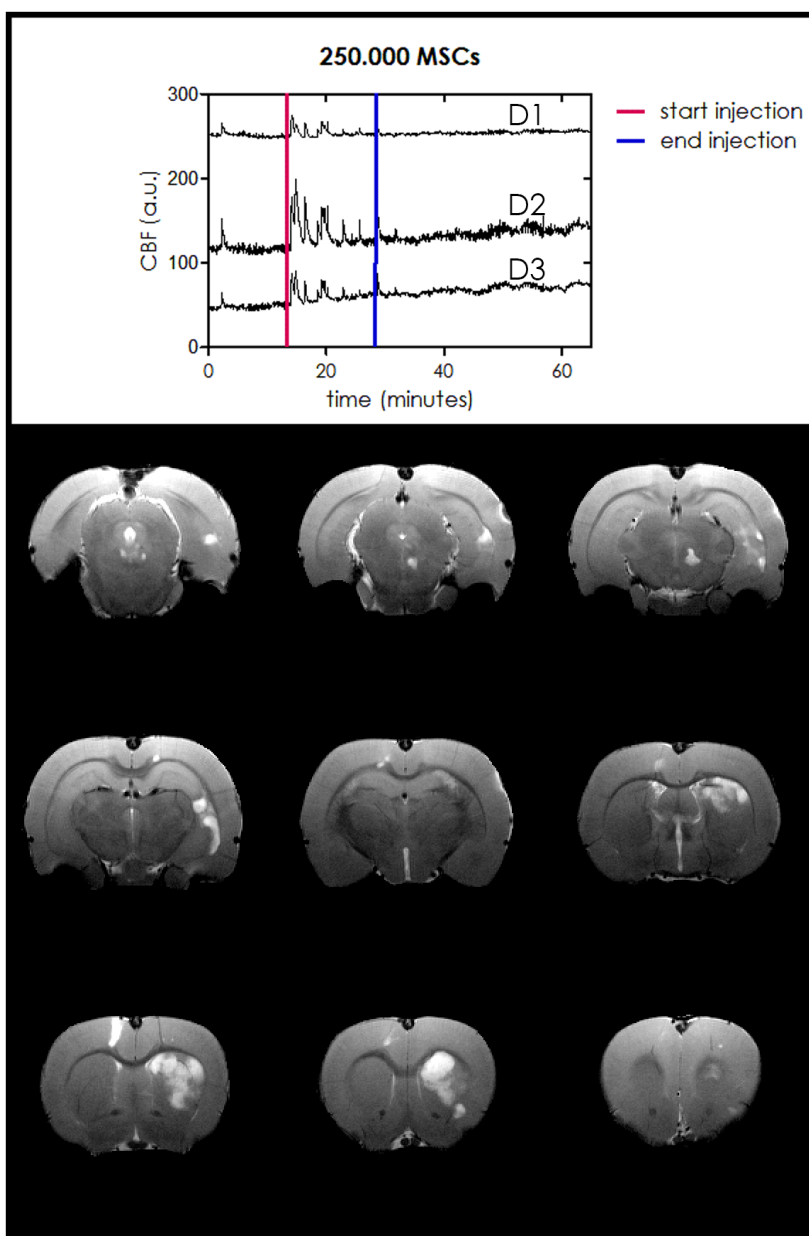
CBF for 3 Doppler probes measured before, during and after the injection of 0.25×10^6 MSCs; and MR T₂ weighted images of several brain slices 24h after the cell delivery.
